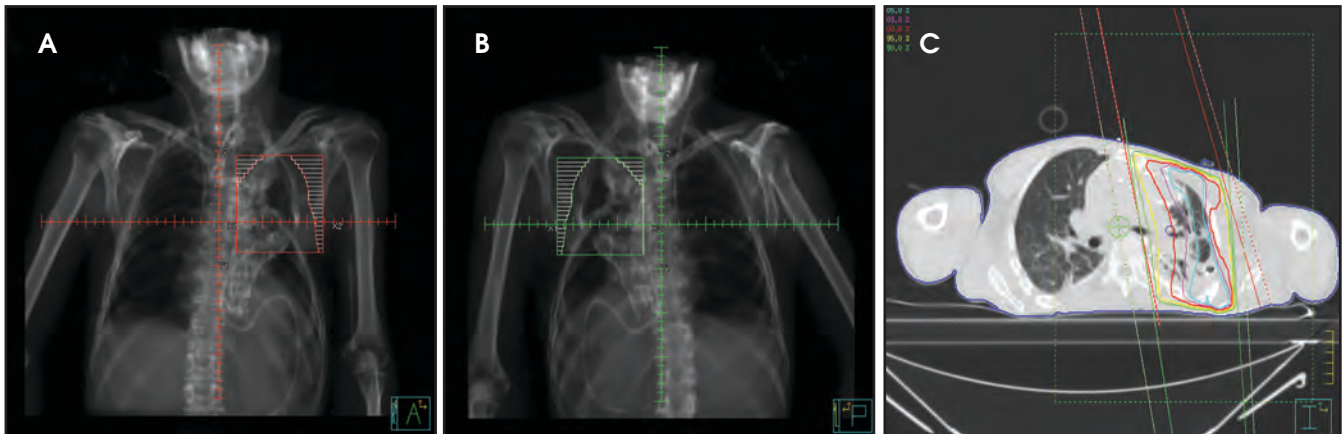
Digitally reconstructed radiographs of a parallel-opposed pair anterior (A) and posterior (B) beams. Representative axial cross section (C) showing isodose lines. Light blue represents 105% of normal, magenta 103%, red 100%, yellow 95% and green 90%.
